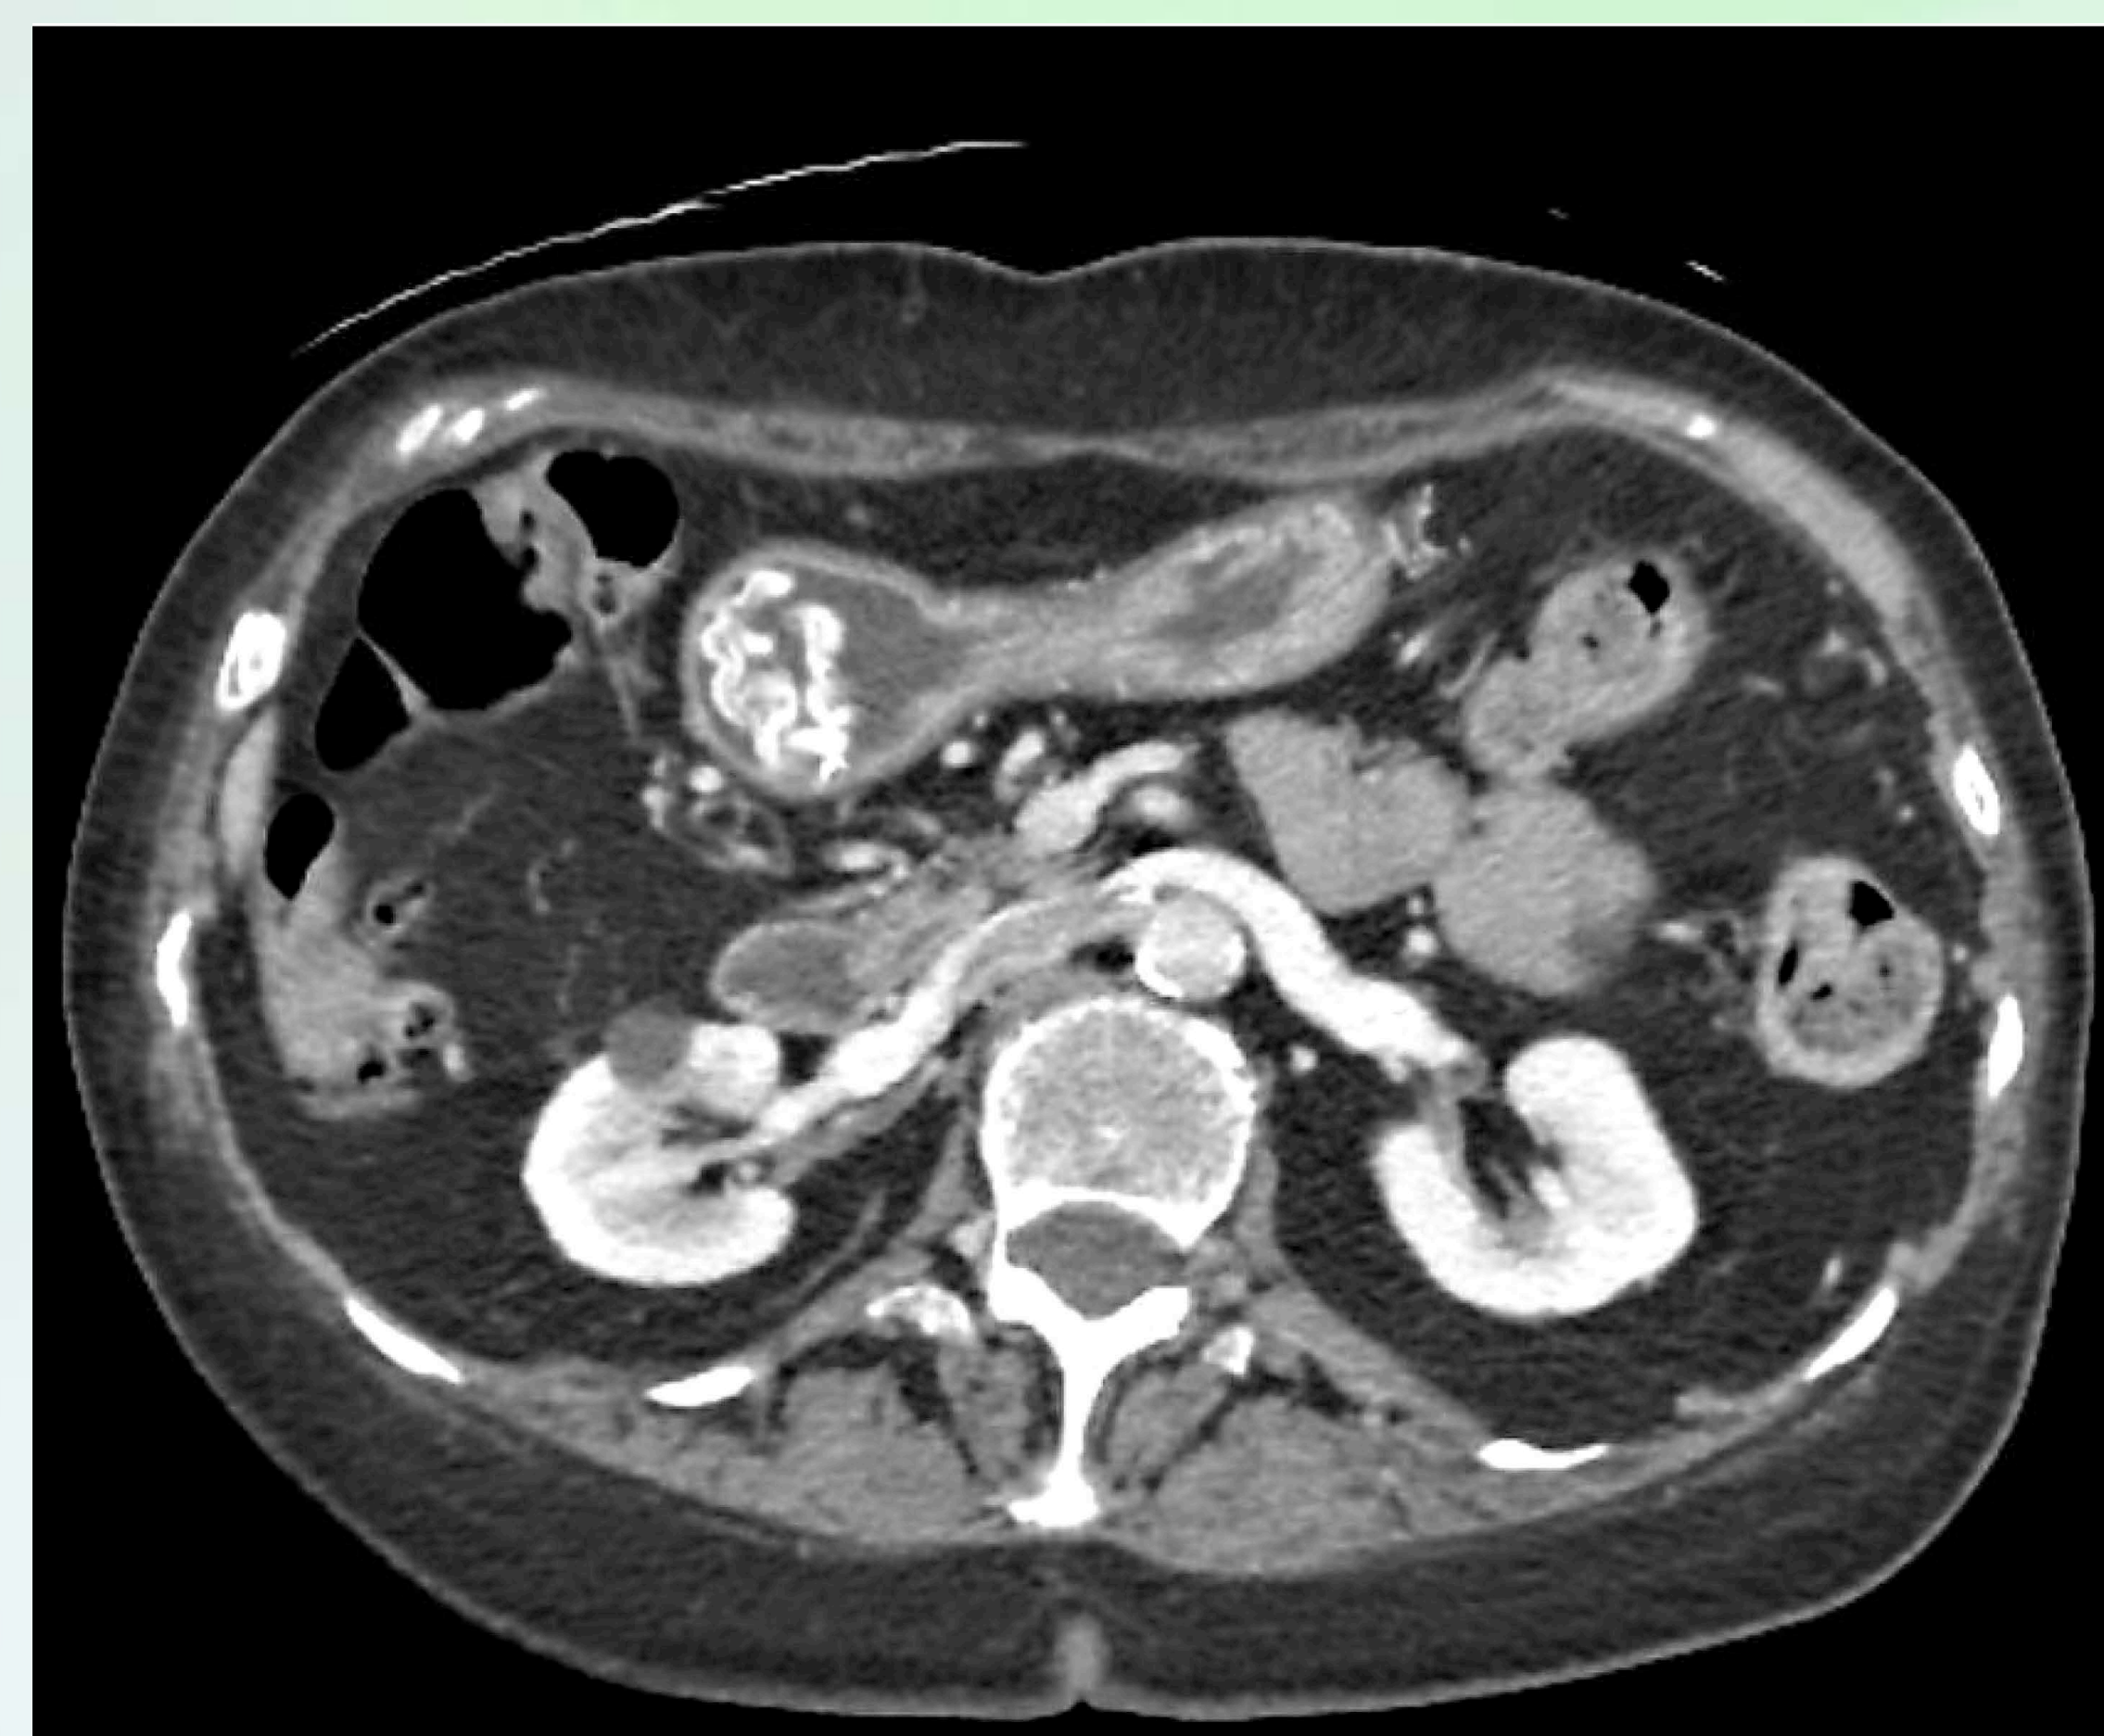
CT of abdomen and pelvis demonstrating a thin radiopaque object with multiple ring foci of metallic density within the distal stomach.
